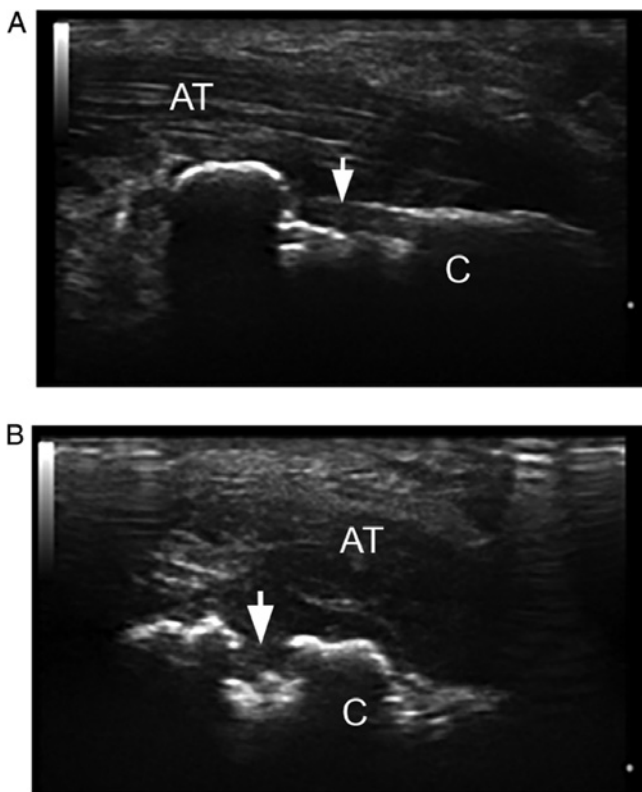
Grey scale US of Achilles tendon. (A) Longitudinal and (B) transverse scan: Hypoechoic Achilles tendon (AT), with loss of the fibrillar pattern, mostly near to the cortical calcaneus (C in the images) bone (<2 mm), findings suggestive for enthesitis. Moreover, we observed erosion (arrow), like step-down changes, identified in two perpendicular views. US, ultrasonography; AT, Achilles tendon; C, calcaneus (Esaote, MyLab25 18 MHz).
